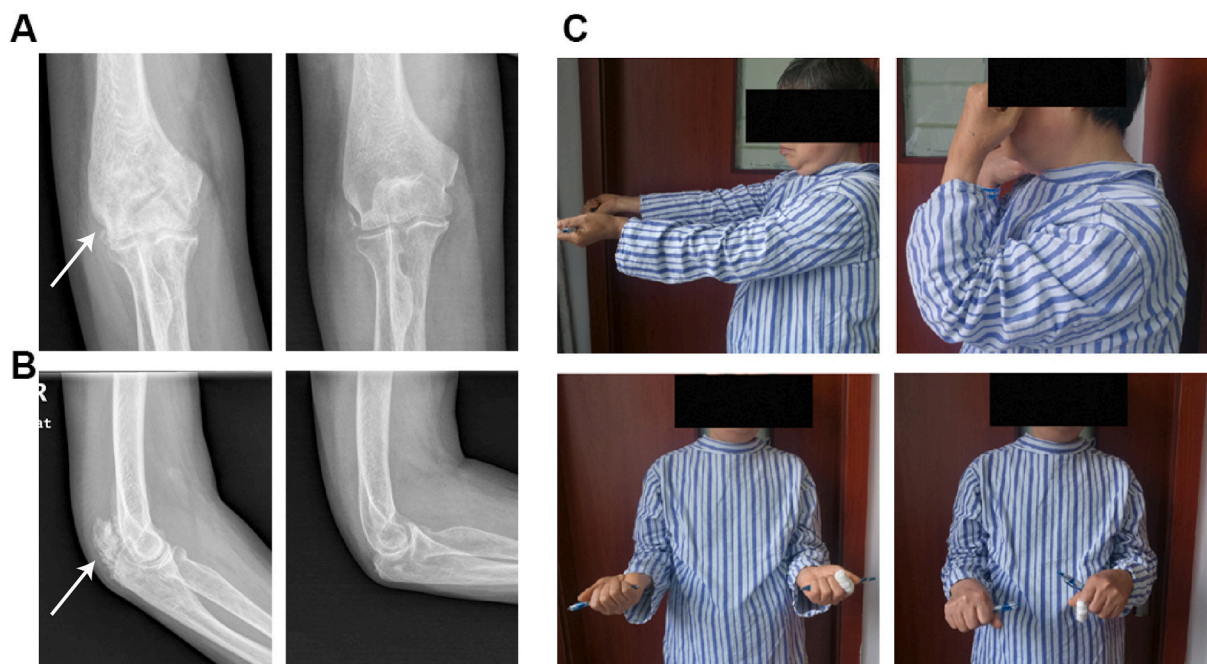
Therapeutic effects on HO patients. (A) A radiograph of an elbow joint of a patient with HO in the lateral position. Left: before treatment; right: after treatment. (B) A radiograph of an elbow joint of a patient with HO in the anteroposterior position. Left: before treatment; right: after treatment. (C) The functionality of the elbow joint.
